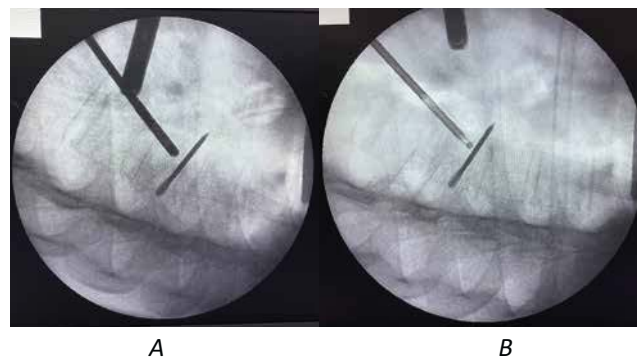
Radio control of the video thoracoscopic tool navigation using fluorographic x-ray general purpose system of the mobile Carmex RK FP to the location of the metal arrow-shaped element
